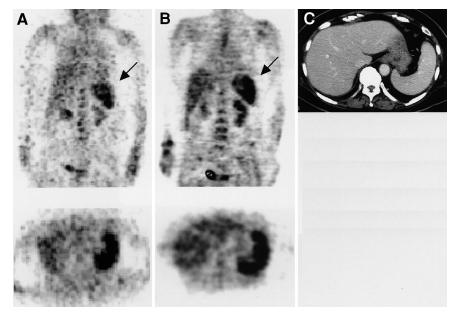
Patient 24. Diffuse spleen involvement (arrows) is detected by both FDG hybrid PET (A) and dedicated PET (B) (top: coronal; bottom: axial). (C) CT fails to detect involvement, showing only splenomegaly.
